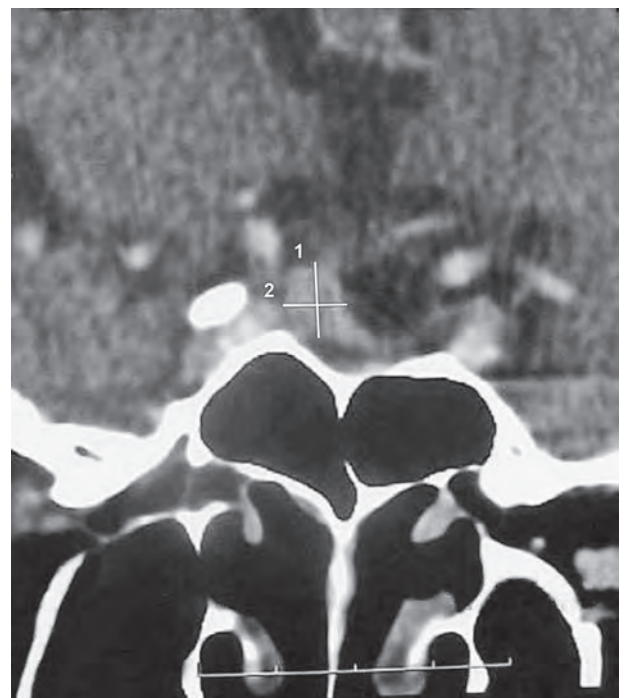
CT coronal section showing the septum in the sphenoid sinus near the midline
